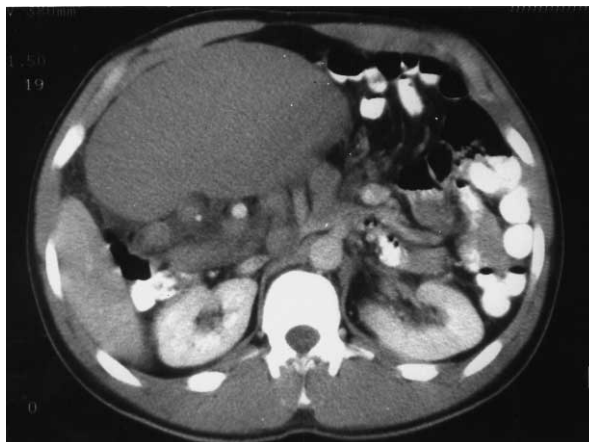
Computed tomography of the abdomen showing an abnormally located spleen in the upper right mid-abdomen.
